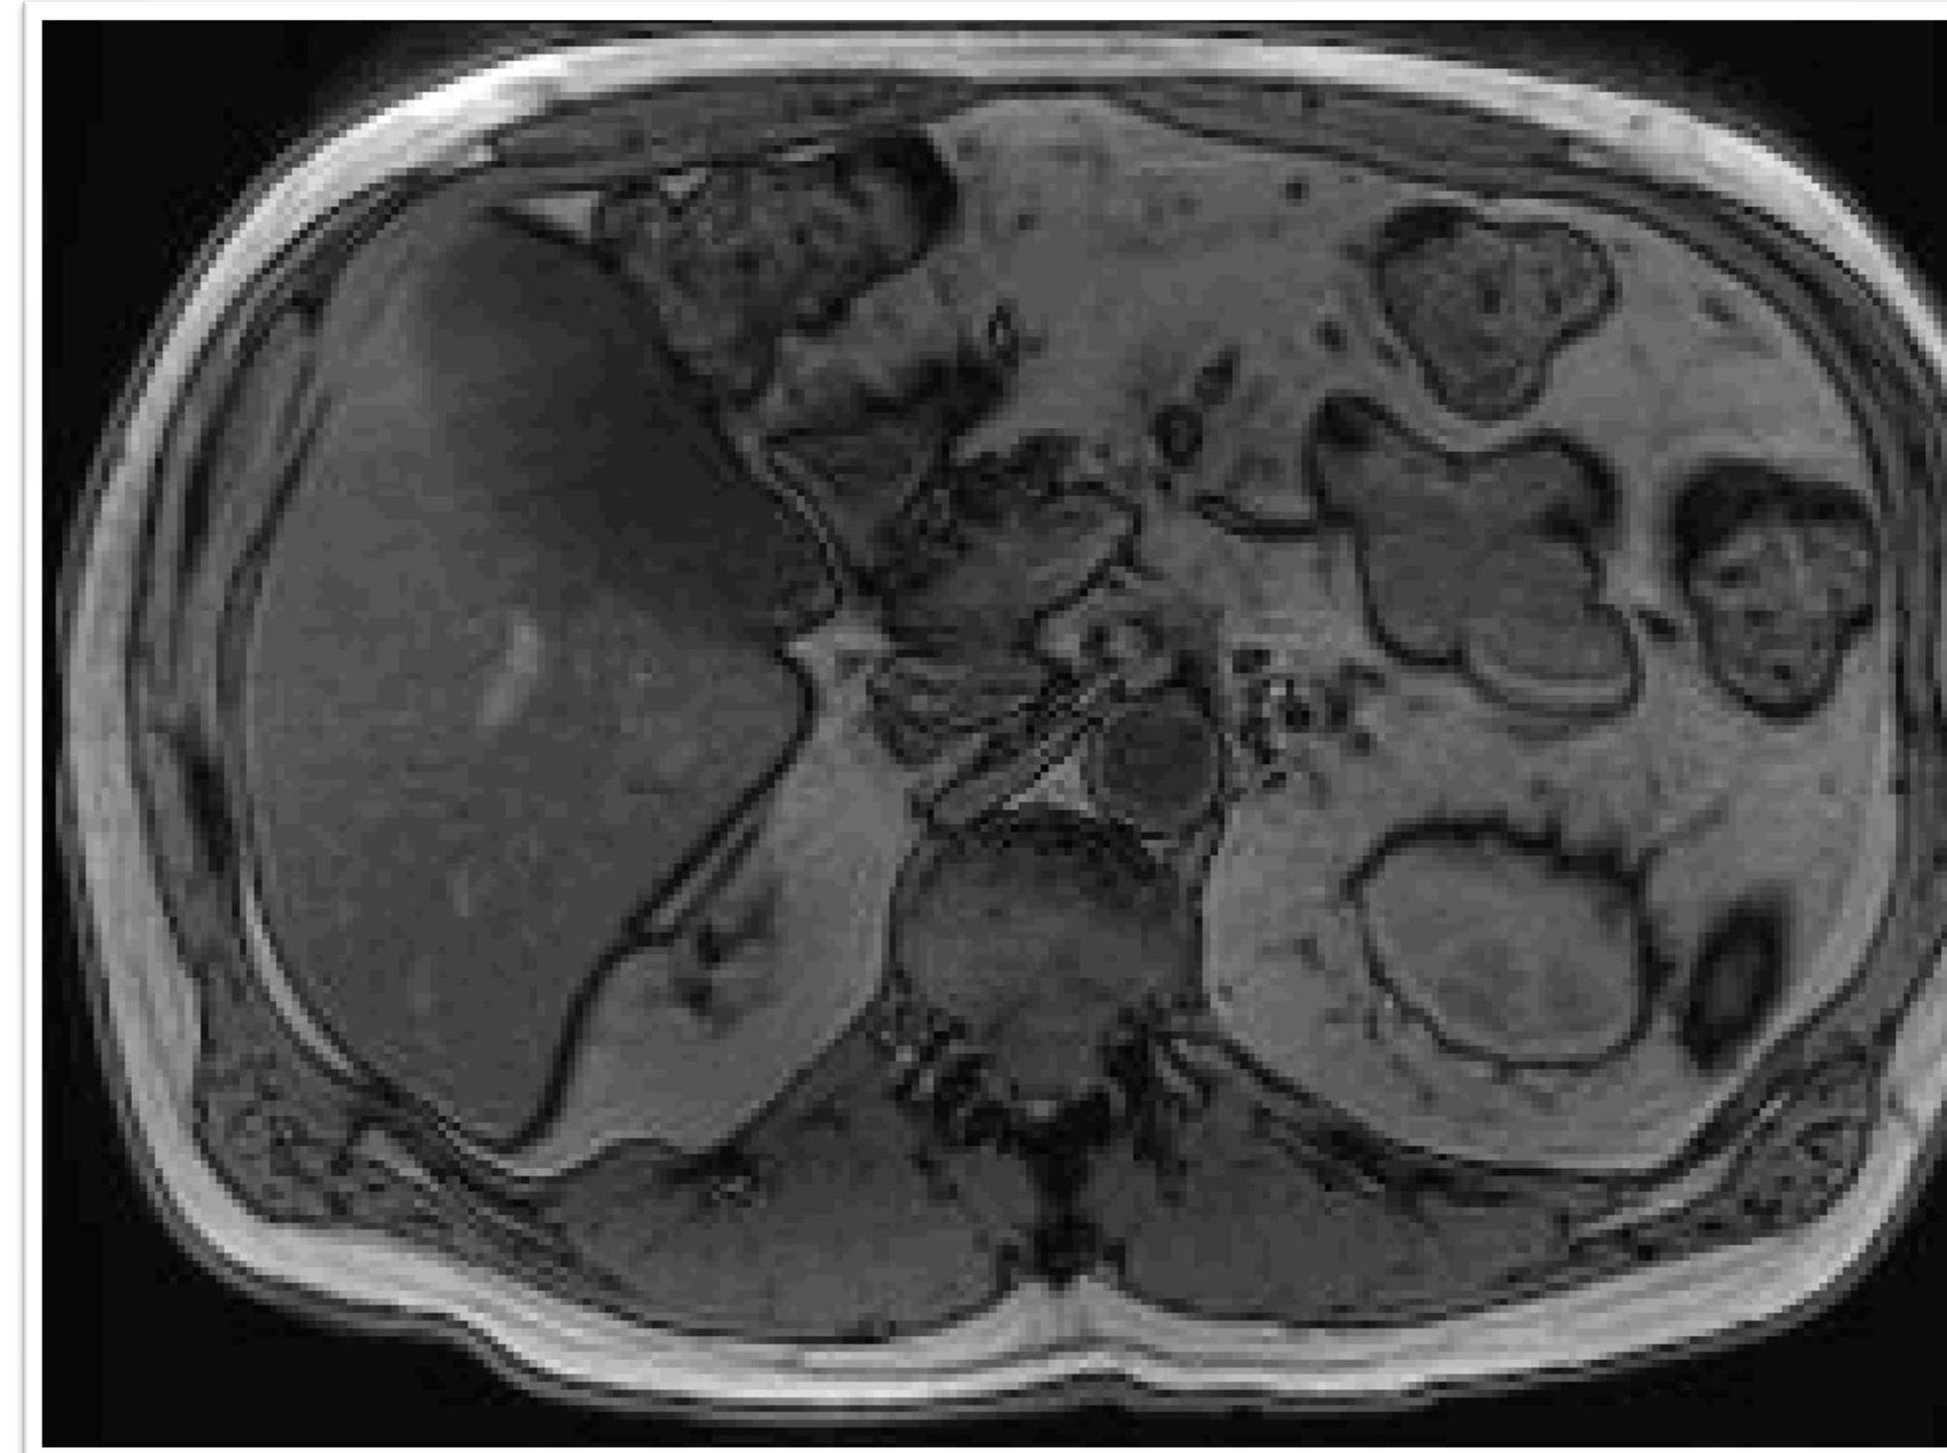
Key images from the MRI abdomen/pelvis obtained during the initial diagnostic workup.
